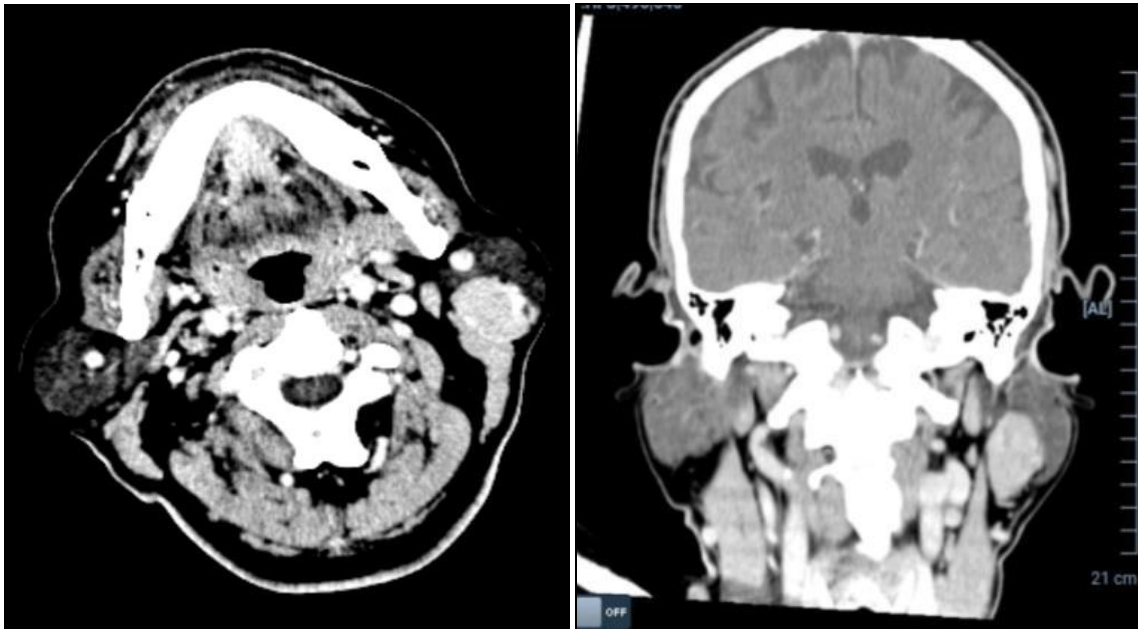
Computed tomography showed a mass on left parotid
